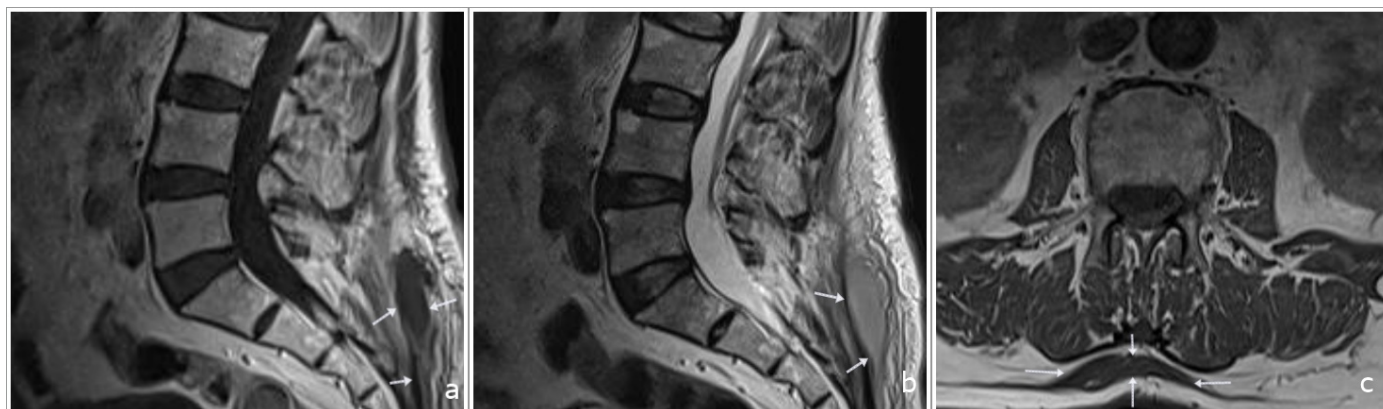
Images of the abscess collection areas on different MRI sections: a) T1-weighted sagittal, b) T2-weighted sagittal, and c) T1-weighted axial.
